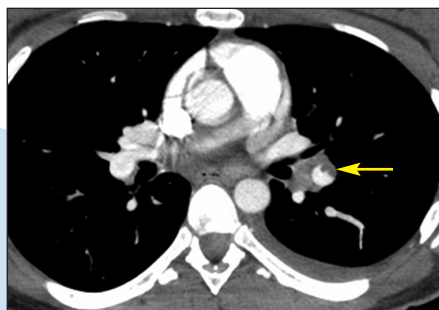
CT pulmonary angiogram shows an incomplete filling defect in the left lower lobe pulmonary artery (arrow) that forms acute angles with the arterial wall, indicating an acute pulmonary embolus. Note there is also a small left pleural effusion.
